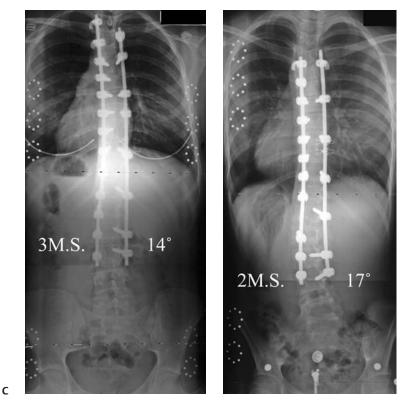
(*Continued*) Two-year postoperative PA radiographs of patients with four different deformity-flexibility quotients (DFQ = residual lumbar deformity divided by number of unused motion
